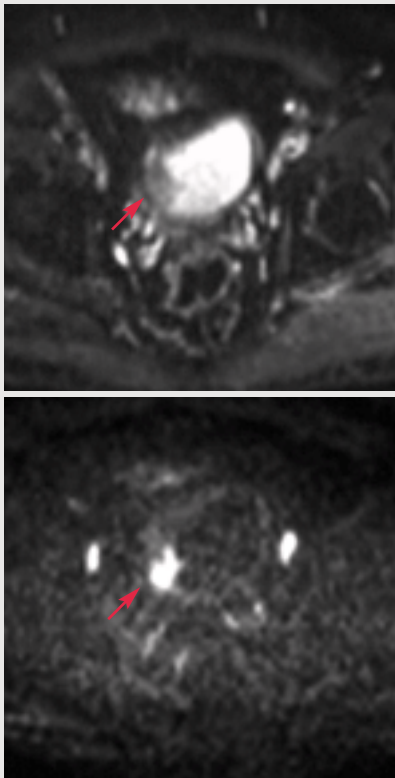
Urinary bladder wall DWI shows that the thickened wall contains tumorous tissue.
